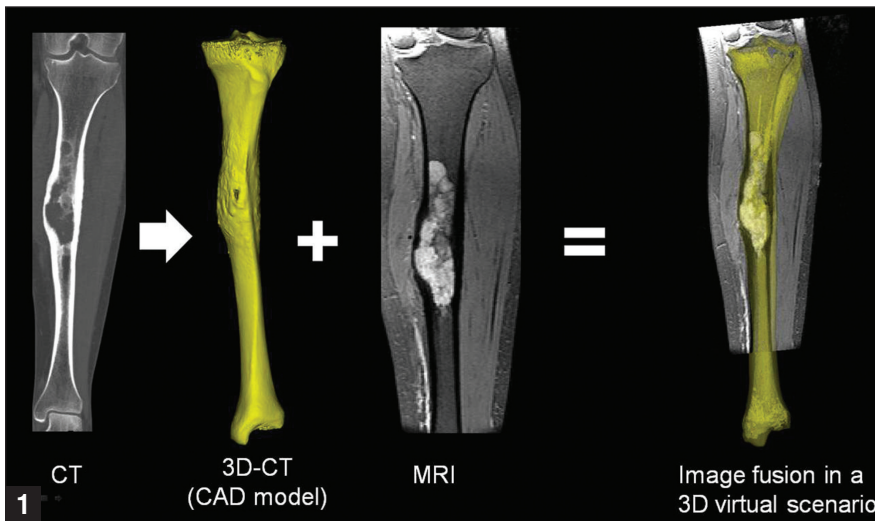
Image fusion of patient 28. Computed tomography (CT) scans were obtained of a tibia diaphyseal chondrosarcoma to create a computer-aided design (CAD) model and were then merged with magnetic resonance images (MRIs). Abbreviation: 3-D, 3-dimensional.
